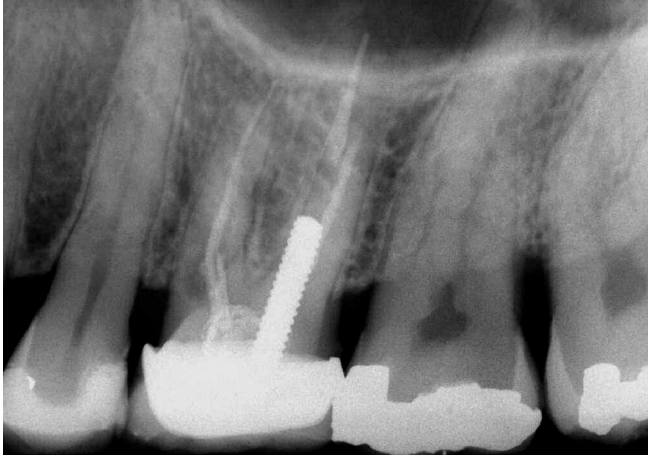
A radiograph shows incomplete endodontics and resultant failure. Note the poor fitting crown, internal resorption, furcal involvement and the large post.
